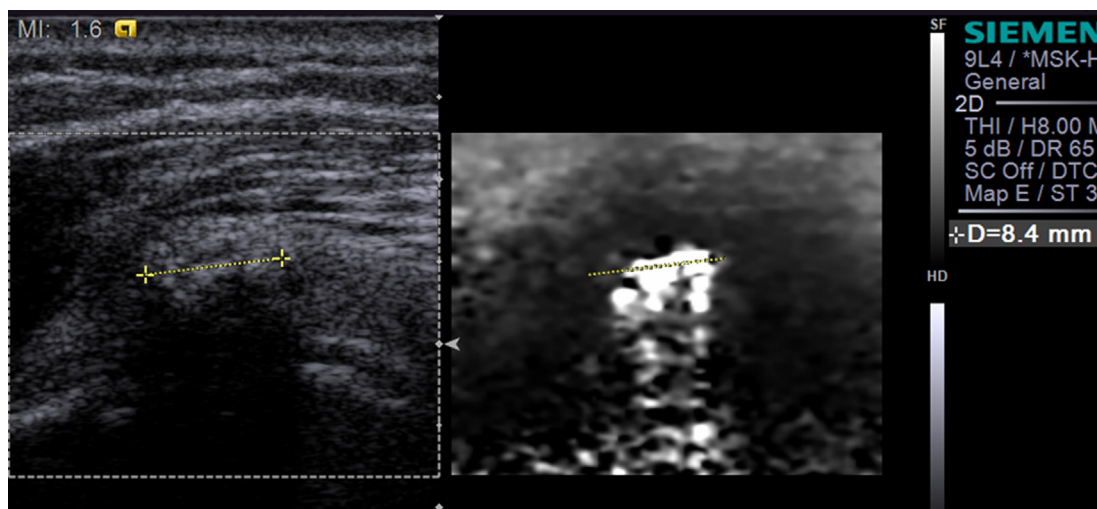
Imaging studies from a 52-year-old woman who complained of left shoulder pain for 1 year. Gray-scale ultrasound (US) showed fragmented calcification (dotted line), and elastography exhibited a bright pattern (dotted line). This patient received US-guided aspiration, and had pain relief.
